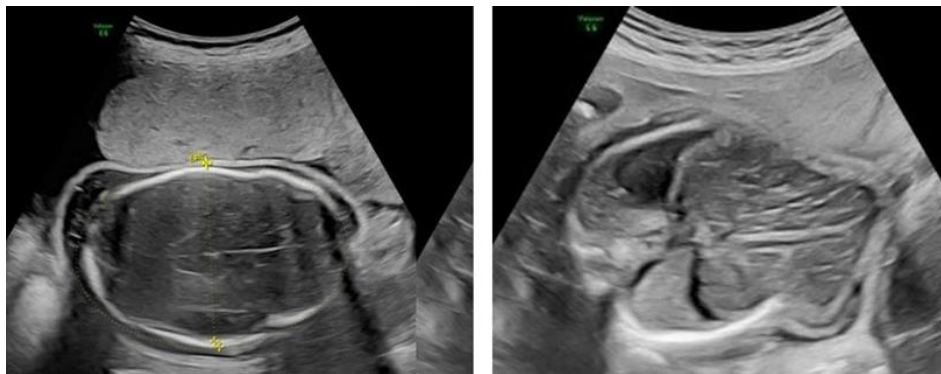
Ultrasonography of the fetus shows features of non-immune hydrops. (a) Scalp oedema is seen as a double-contour halo around the fetal cranium. (b) Axial image of the fetal thorax demonstrates bilateral pleural effusion.
